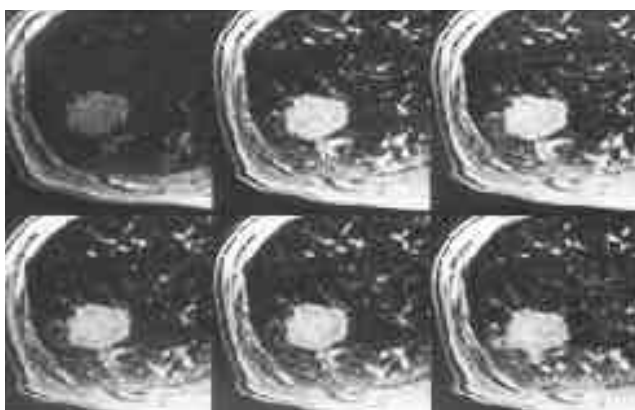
73-year-old man with small cell carcinoma (patient 8). Serial MR images show homogeneous enhancement of SPN. The p%SI is reached in 2 minutes after contrast enhancement (Top right).
